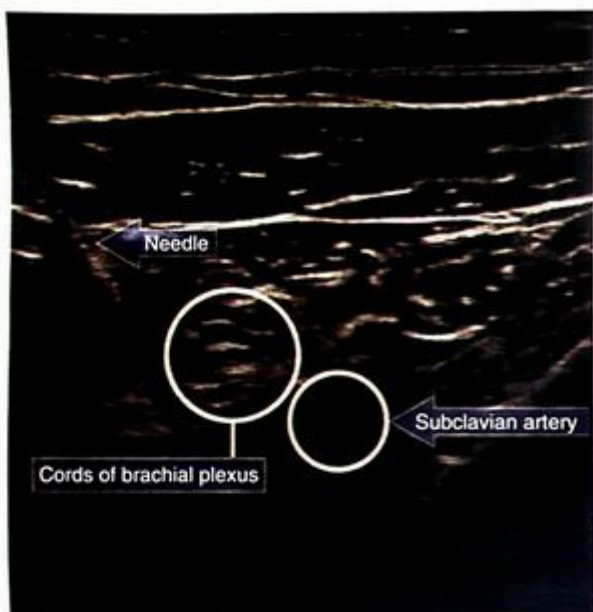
Ultrasound image of the brachial plexus and needle path using the costoclavicular approach. (Image courtesy Eriq Farag MD, FRCA.)
